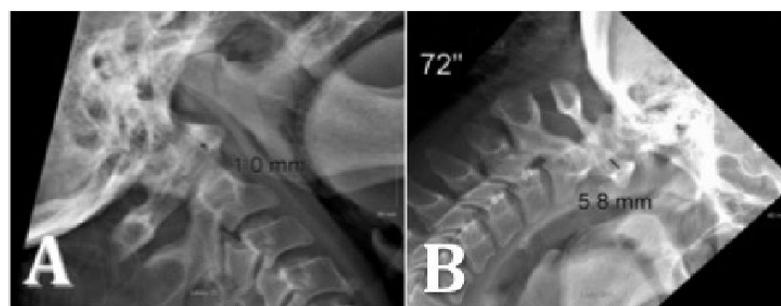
Demonstration of atlantoaxial instability by radiography showing an atlantoaxial interval greater than 5.0 mm.
